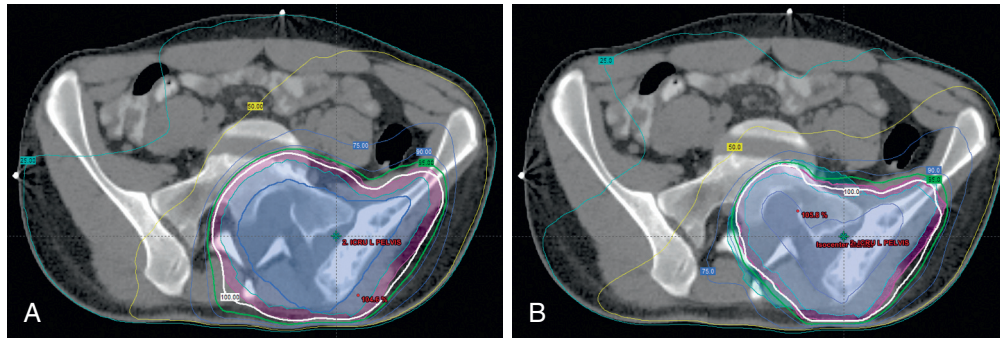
A, Dose distribution resulting from computed tomography (CT)-based intensity modulated radiotherapy treatment following induction chemotherapy for prechemotherapy planning target volume (PTV) receiving 45 Gy. B, Dose distribution resulting from CT-based intensity-modulated radiotherapy treatment following induction chemotherapy for postchemotherapy PTV receiving 10.8 Gy boost.
